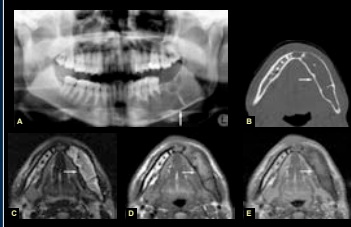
Keratocystic odontogenic tumor, mandible: 33-year-old male, painless paranasal swelling of lower lip. A: Painless, slow swelling of lower lip and lower mandible. B: Axial CT image shows well-defined bone with expansion of buccal cortical bone, which is very thin and partially absent (arrow). C: Coronal CT image shows multilocular appearance in inferior part (arrow) and cortical outline (arrow). D: Coronal MRI image shows multilocular appearance and heterogeneous intermediate to high signal (arrow). E: Axial T2-weighted MRI shows high signal in posterior part (arrow) and intermediate signal in anterior part (arrow).
